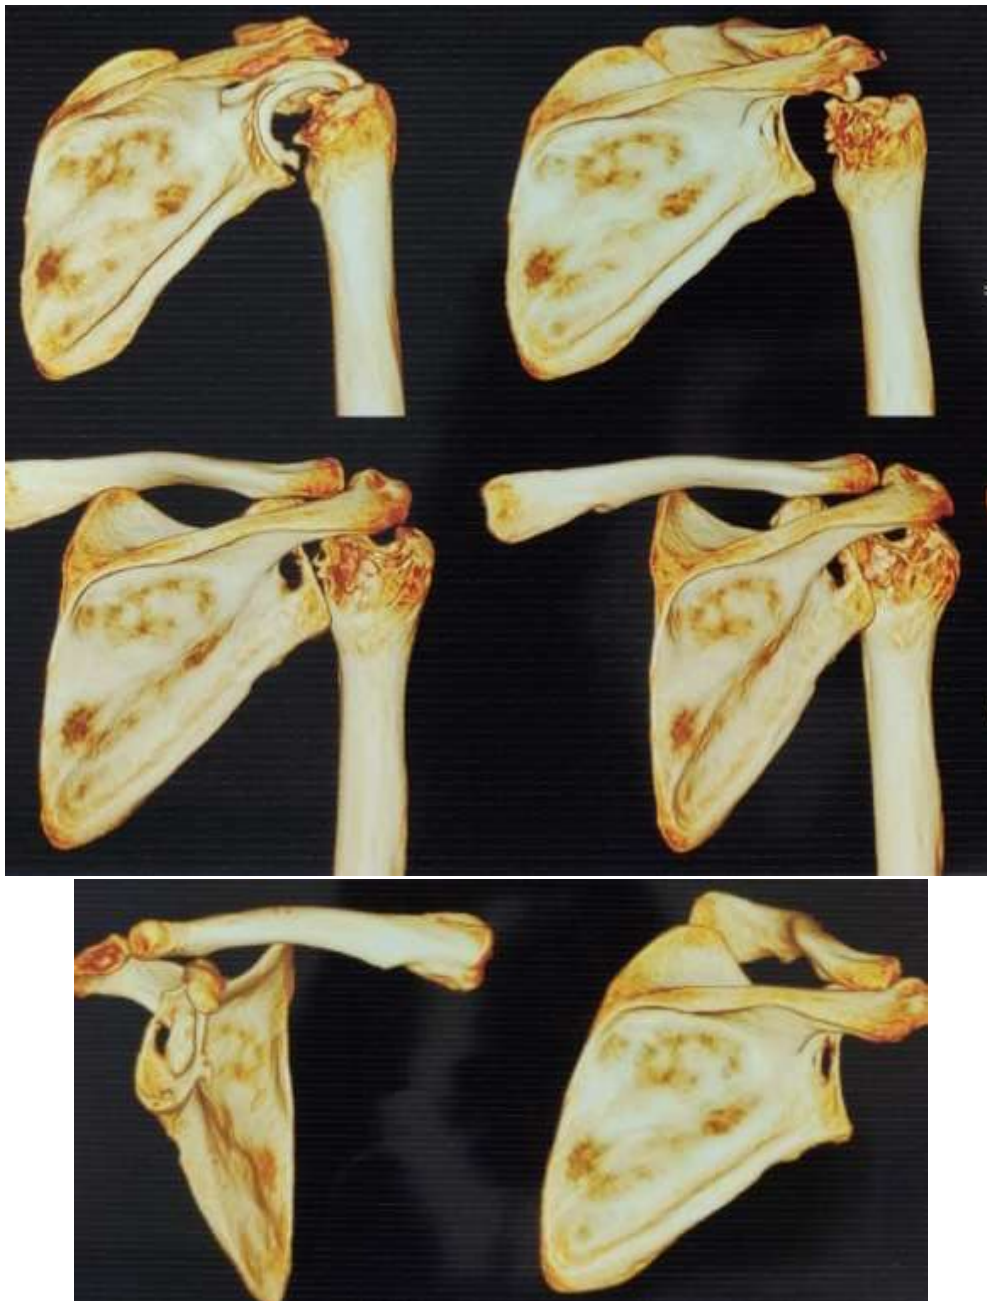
3D-CT showing erosion and destruction of right humeral head along with glenoid.
